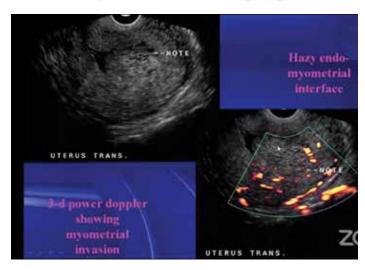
3D power doppler showing myometrial invasion
